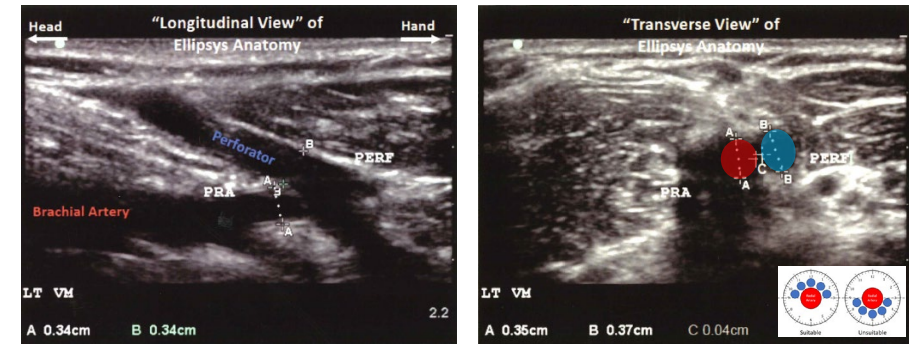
Example target images for Ellipsys endovascular arteriovenous fistula mapping with ultrasound. Images from [Ellipsys Vascular Access System - Arteriovenous Fistula \(AVF\) Creation | Medtronic](#)
